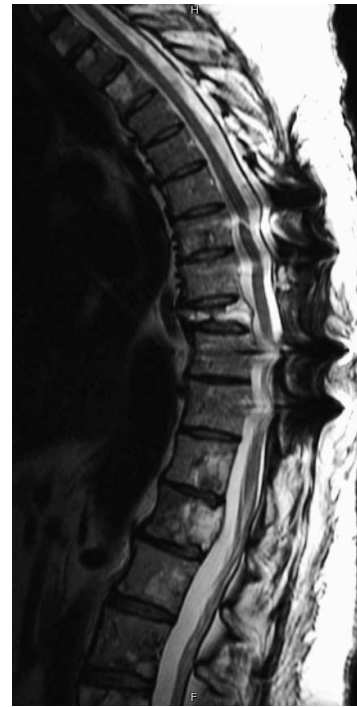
Post-operative T2 magnetic resonance imaging of thoracic spine at 1.5 years showing stable disease.
